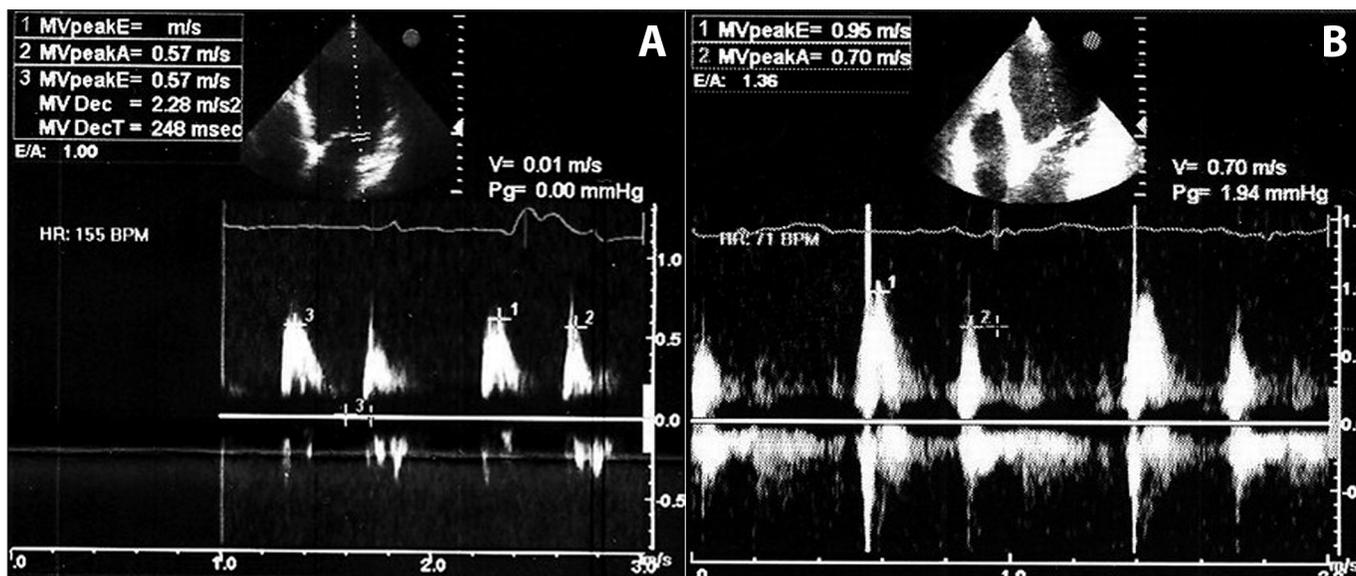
Pulsed Doppler assessment of left ventricular (LV) inflow before enhanced external counterpulsation (EECP) (A), and pulsed Doppler assessment of LV inflow after EECP (B).
